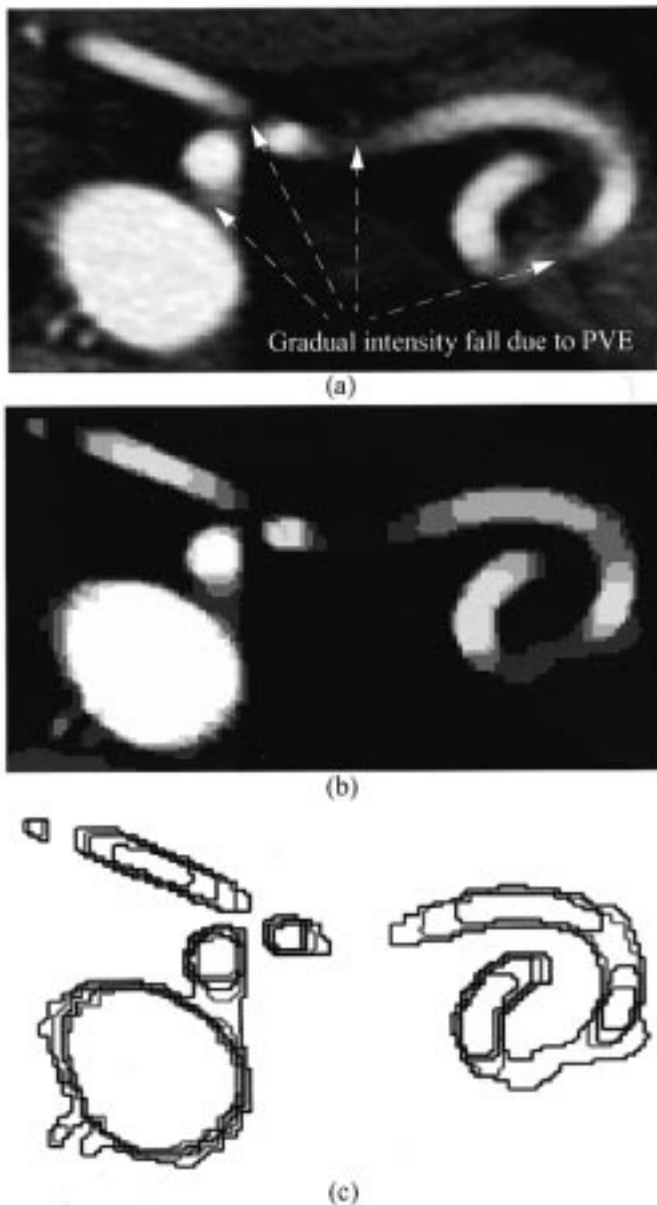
A CTA section and its isolabel-contour map. (a) The raw section. Note the gradual intensity fall due to extensive PVE where the vessel is oriented at a small angle with respect to the image plane. (b) The isolabel-contour map. The map resulted from a seven-threshold partition of the intensity range. Note the saddle-like patterns of isolabel contours for the branching and tortuous vessel. (c) Contour patterns for the major structures in (a). For clarity, the figure shows only the contours that correspond to the six highest thresholds, and displays the contours in a variety of grayscale values. Note that the contour patterns are dense along sharp intensity gradients and are more widespread where intensity falls gradually.
